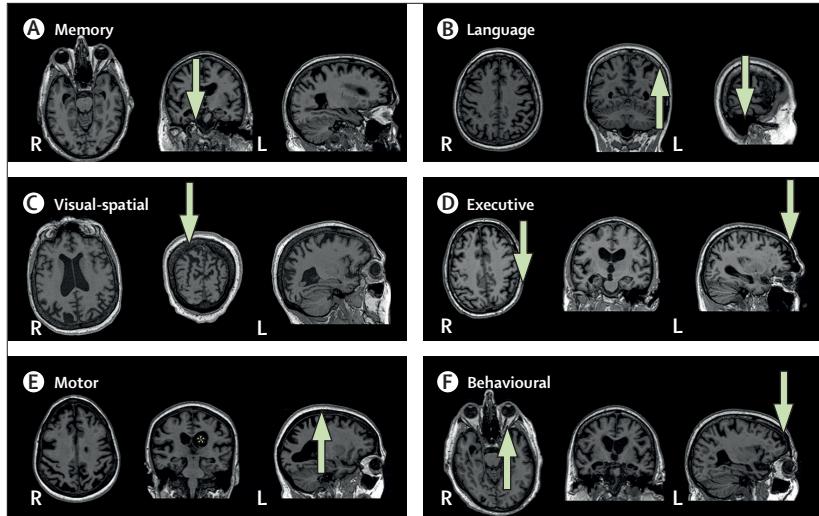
MRI across Alzheimer's disease phenotypes
